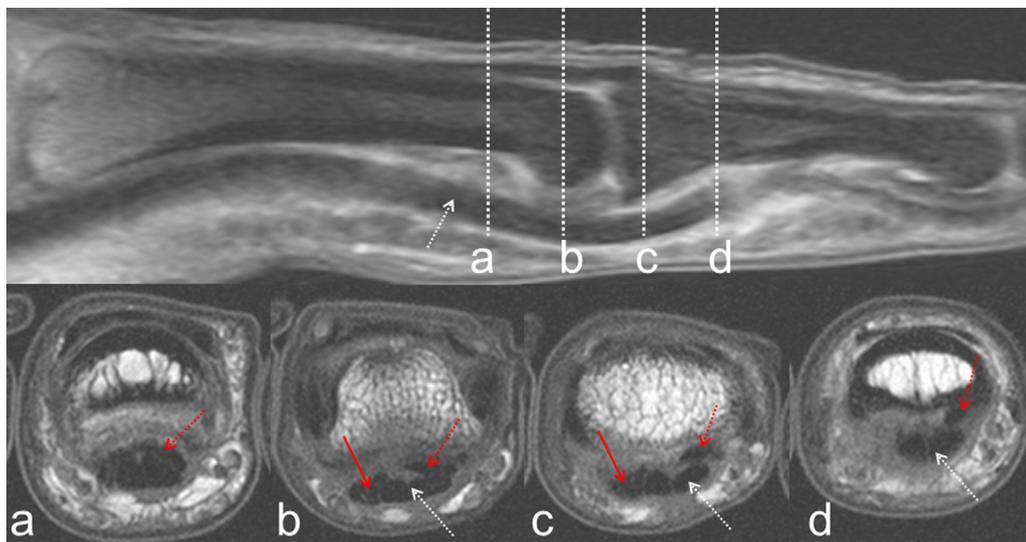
Proton density weighted MRI showing sagittal and cross sections in the transverse (axial) direction (a–d). Disrupted and crimped up radial FDS slip (red continuous arrow), intact ulnar FDS slip (red dotted arrow), FDP tendon (white dotted arrow), cross section (d) showing a void where the radial FDS tendon slip is disrupted and missing.
